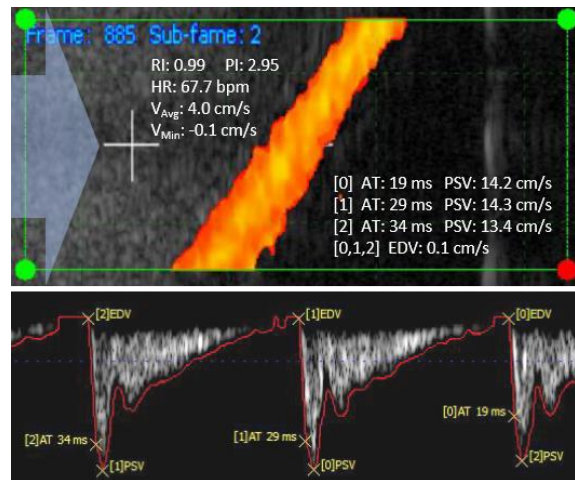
An example of the performance of the developed CFM+PWD Doppler imaging algorithm implemented in the prototype 128-channel ultramobile ultrasound B-mode scanner.
